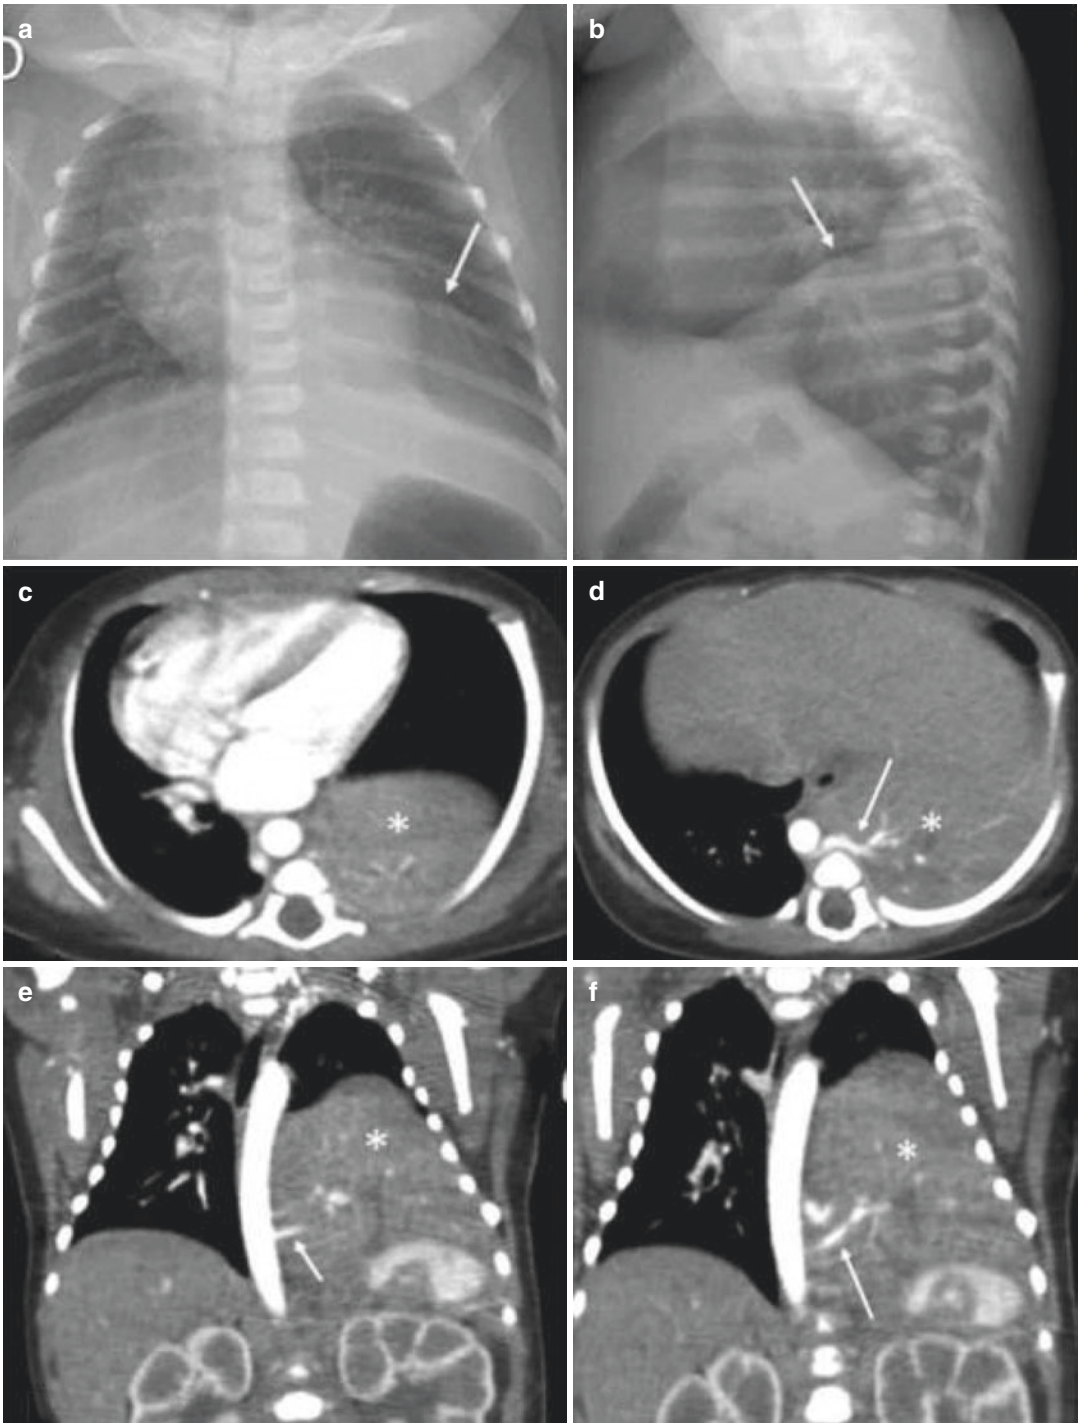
Intralobar pulmonary sequestration of the left lower lobe in a 5-day-old infant who had a prenatal ultrasound suggestive of a congenital pulmonary malformation but was born without respiratory distress. Chest x-rays in the anteroposterior (a) and lateral (b) views show a mass that occupies
